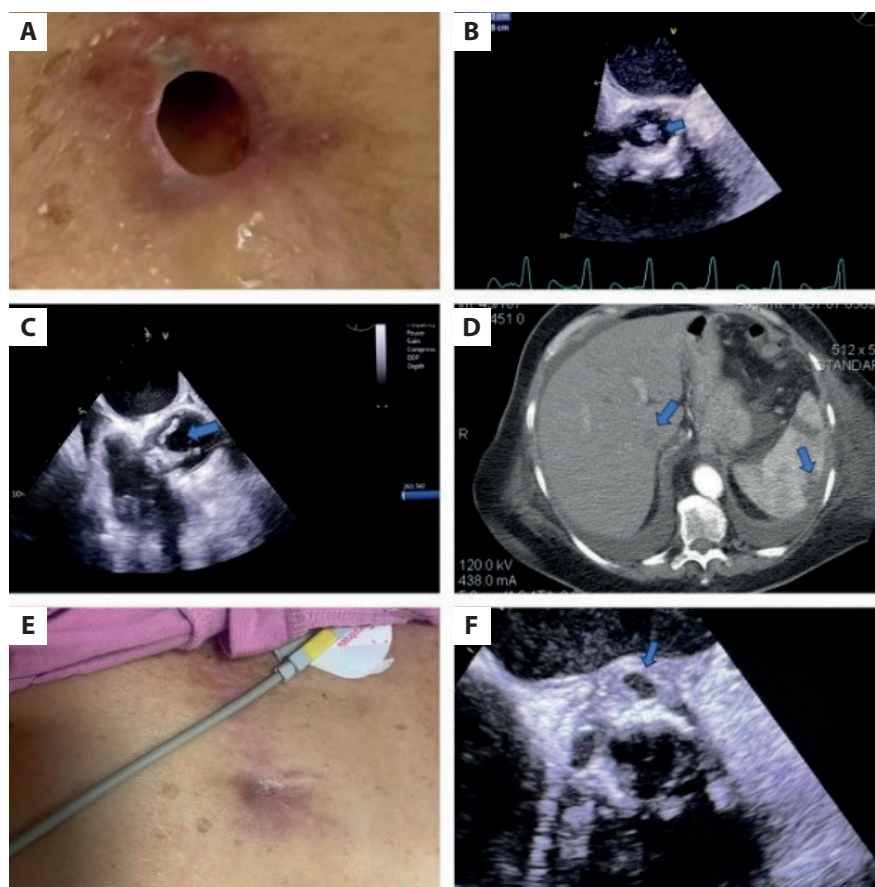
A. Inflammatory tunnel formed from the stitch purulence in the sternum. B. Transesophageal echocardiogram, short axis view, with the presence of vegetation on the vascular side of the aortic valve (blue arrow). C. Transesophageal heart echocardiogram, long axis view, with the presence of vegetation on the vascular side of the aortic valve (blue arrow). D. Computed tomography scan showing the presence of septic hepatic and splenic emboli (blue arrows). E. Healing of the sternum tunnel after antibiotic treatment. F. Transesophageal heart echocardiographic follow-up showing the formation of paravalvular abscess — blue arrow
